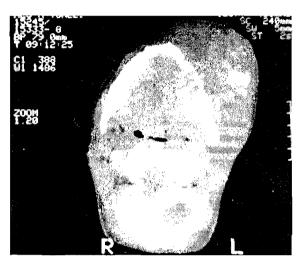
Computed tomograph below mandibular alveolar bone showing bone destruction and tumour calcification in soft tissue mass.
